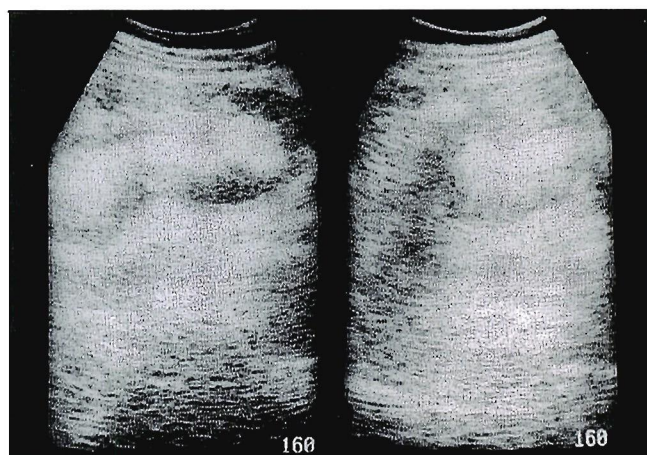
Abdominal ultrasonography revealing a pseudokidney sign in the longitudinal view (left, arrow) and the target sign on transverse view (right, arrow head).
